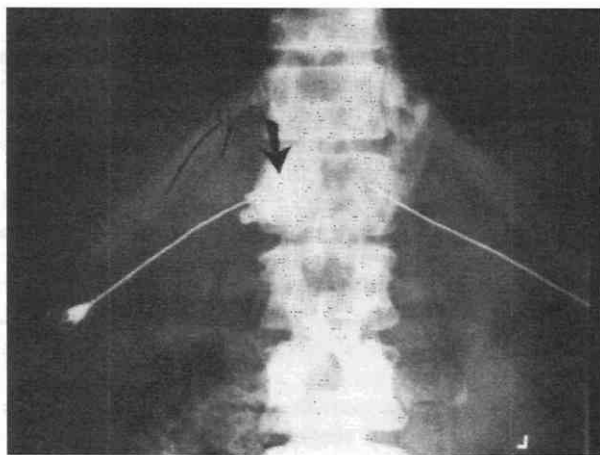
Radiograph of a patient with fluoroscopic localization for a celiac nerve block shows injection of contrast material (arrow). Permanent paraplegia developed after the procedure, despite the interventionist's considerable fluoroscopic experience and meticulous fluoroscopic technique.
